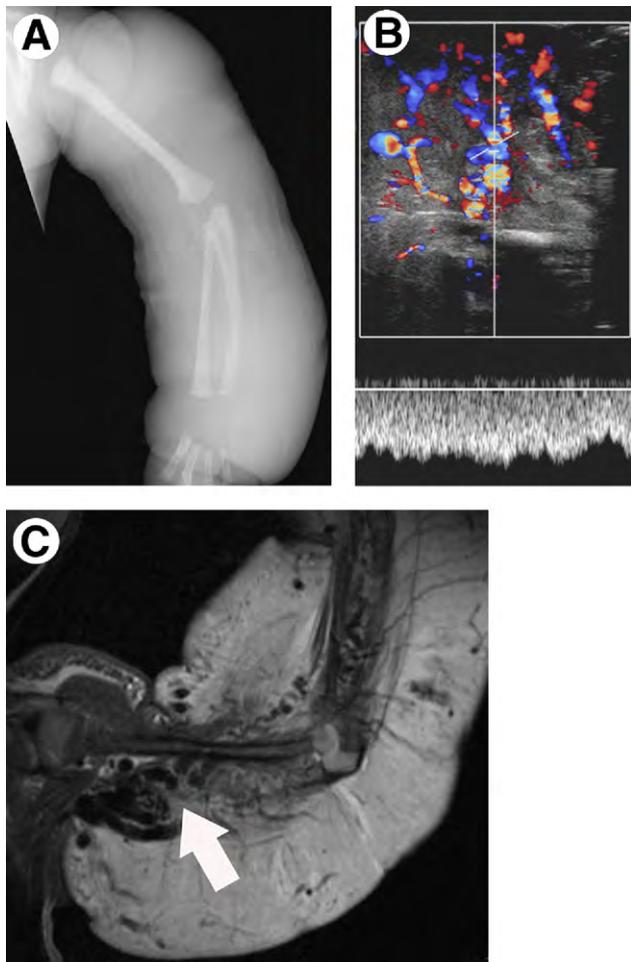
Rapidly involuting congenital hemangioma in a newborn female with severe swelling, high-output cardiac failure and thrombocytopenia. (A) Plain radiograph of the arm shows soft tissue swelling without bony deformity or soft tissue calcification. (B) Color Doppler sonogram reveals a poorly defined hypervascular mass with venous waveforms. Large internal flow voids and arterial waveforms were also present (not shown). (C) Sagittal contrast-enhanced T1-weighted fat-suppressed image reveals extensive enhancement throughout the thickened soft tissues of the arm with innumerable large flow voids (arrow).
